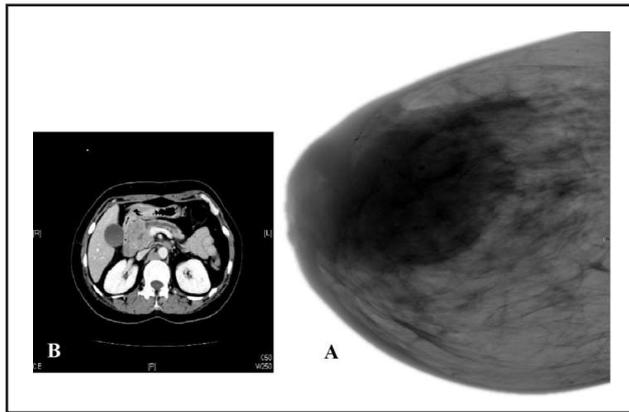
(A) right central malignant breast mass, and (B) Computed tomography of abdomen showing a pancreatic head mass of size 3.7 x 4.2 cm, compressing the main pancreatic duct
